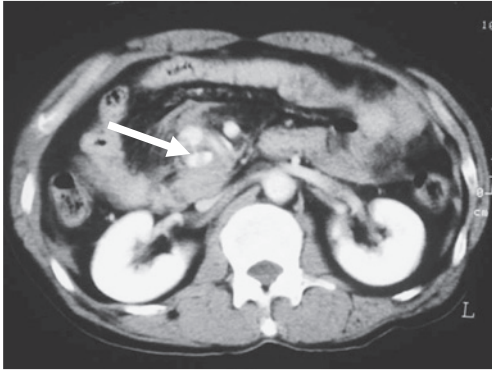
Abdominal CT scan demonstrating a hematoma around the root of the mesentery and extravasation of contrast material (arrow).
